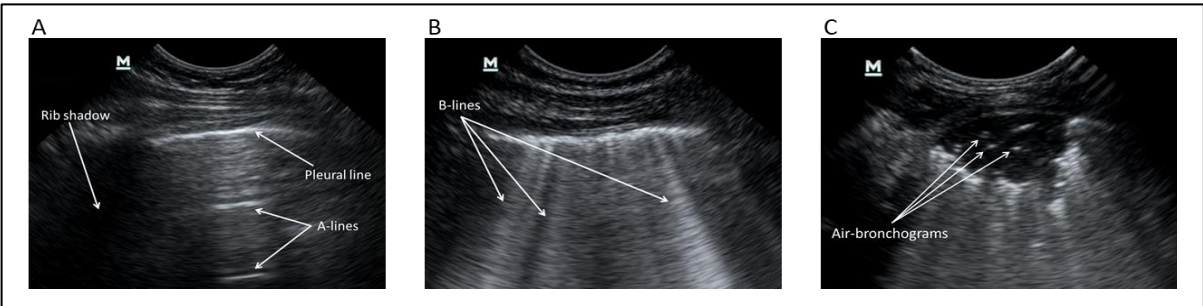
Examples of characteristic sonographic findings in pneumonia: (A) healthy lung characterized by a smooth pleural line with parallel running A-lines, but no (or minimal) B-lines; (B) interstitial disease picture characterized by an irregular pleural line with multiple or confluent B-lines; (C) air-space consolidation characterized by a sub-pleural hypoechoic lesion with loss of the over-lying pleural line, irregular (“shredded”) deep borders, and internal hyper-echoic punctate lesion indicating air-bronchograms.
